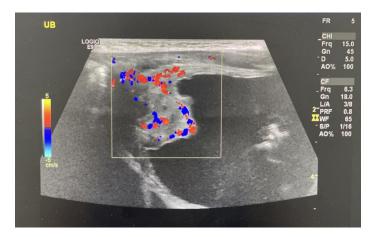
Bladder ultrasound showing a lesion in the apex with internal vascularity
